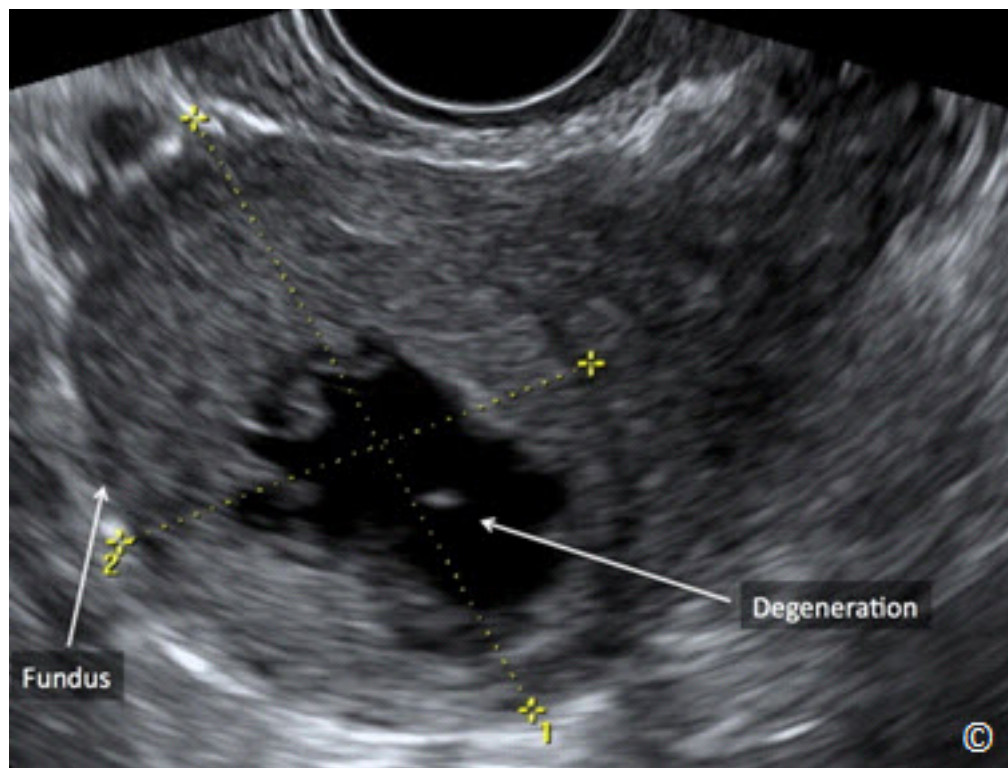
Transvaginal ultrasound showing a hyaline degeneration of an intramural leiomyoma (labeled). The uterine fundus is labeled for image orientation.
